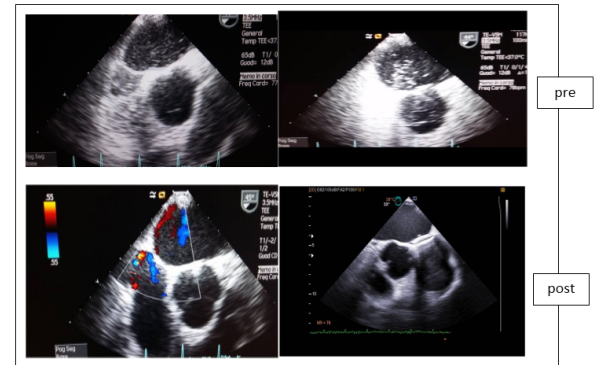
TTE image with microbolle and dopplercolor test; positiveand negative for PFO; pre-after closure
